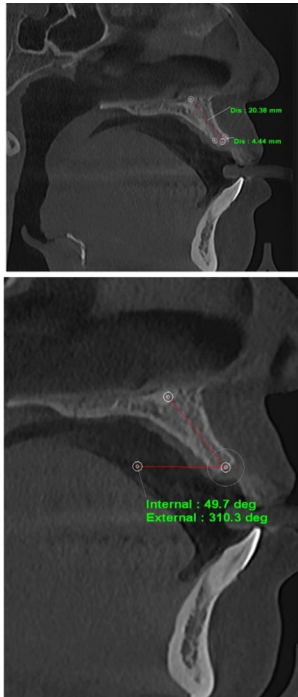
CBCT imaging on sagittal view.
